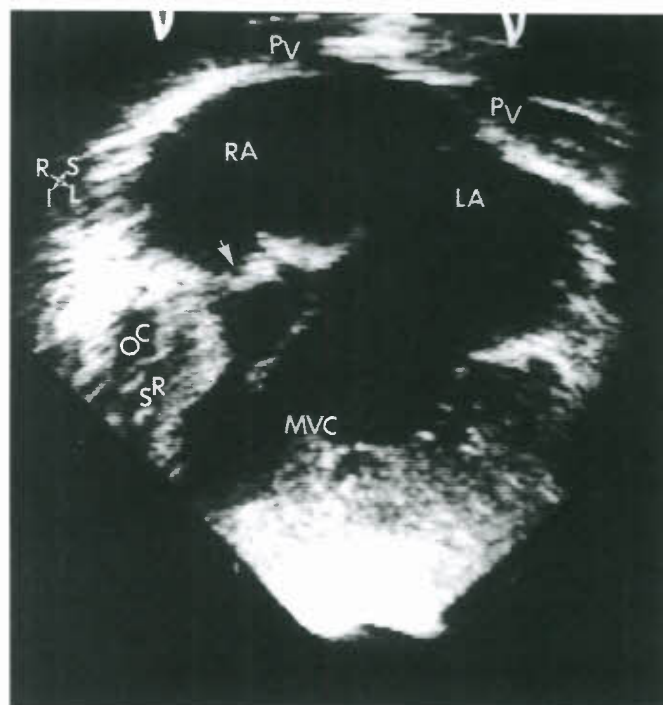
Double inlet with single AV valve. Echocardiogram demonstrating an apical four-chamber view. There is DILV with atresia of the right AV valve. Note that the atretic right AV valve plate (arrow) is directed to the main ventricular chamber (MVC) of left ventricular morphology with malalignment of the atrial and ventricular septa. I, inferior; L, left; LA, left atrium; OC, outlet chamber of right ventricular morphology; PV, pulmonary vein; R, right; RA, right atrium; S, superior; SR, ventricular septal remnant. (From Seward JB, Tajik AJ, Hagler DJ, et al. *Two-dimensional echocardiographic Atlas*. Vol. 1. *Congenital Heart Disease*. New York, NY: Springer-Verlag, 1987:250, with permission.)
